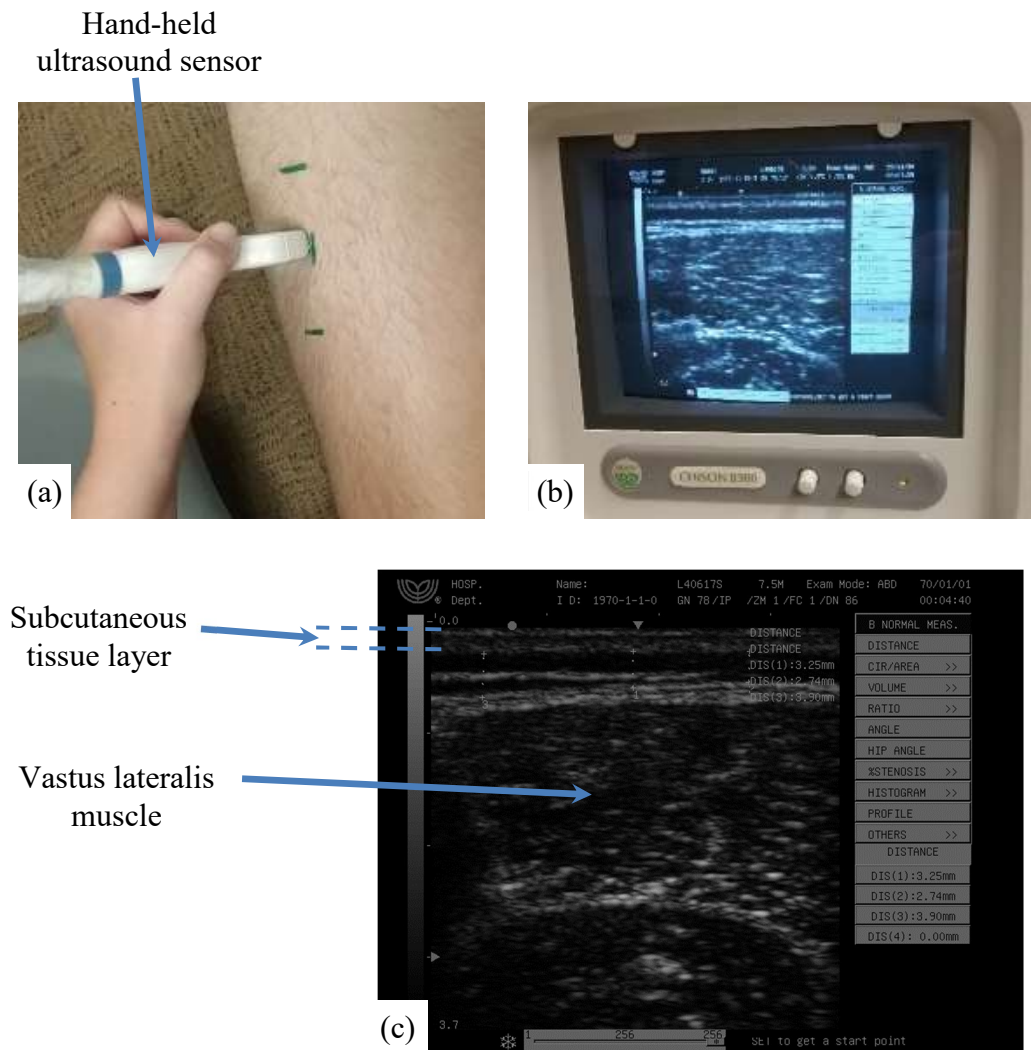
Measuring subcutaneous tissue of fat layer thickness using ultrasound (a) Hand sensor placed over the site of the muscle. (b) Image displayed on the scanner display. (c) Scanned image of muscle.
